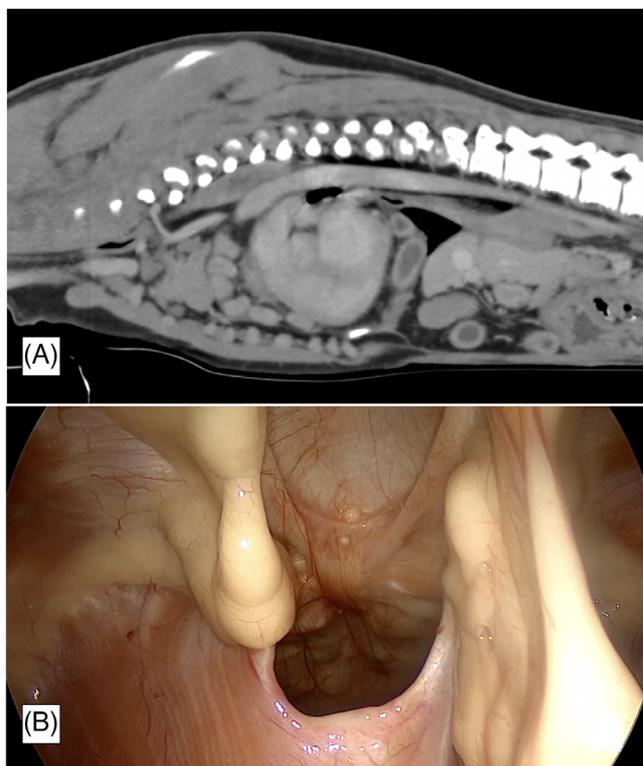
Sternal defect. (A) Computed tomography (CT) lateral view demonstrating sternal defect in the diaphragm. (B) Defect in the diaphragm showing malfusion of the diaphragm with the anterior wall.
